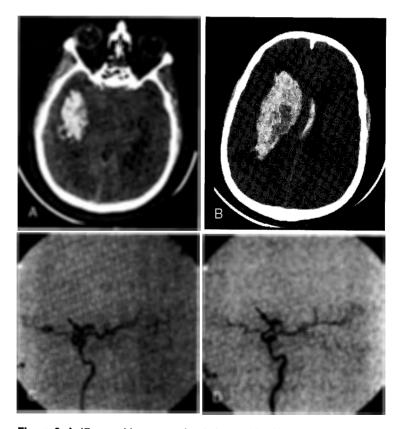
A 47-year-old man, previously in good health, presented with decreased level of consciousness. A CT scan (A and B) was performed that demonstrated an intracranial hemorrhage. An angiogram was performed to assess for a vascular etiology of the hemorrhage; this demonstrated bilateral supraclinoid carotid artery occlusion (*arrows*) consistent with moyamoya disease (C and D).
